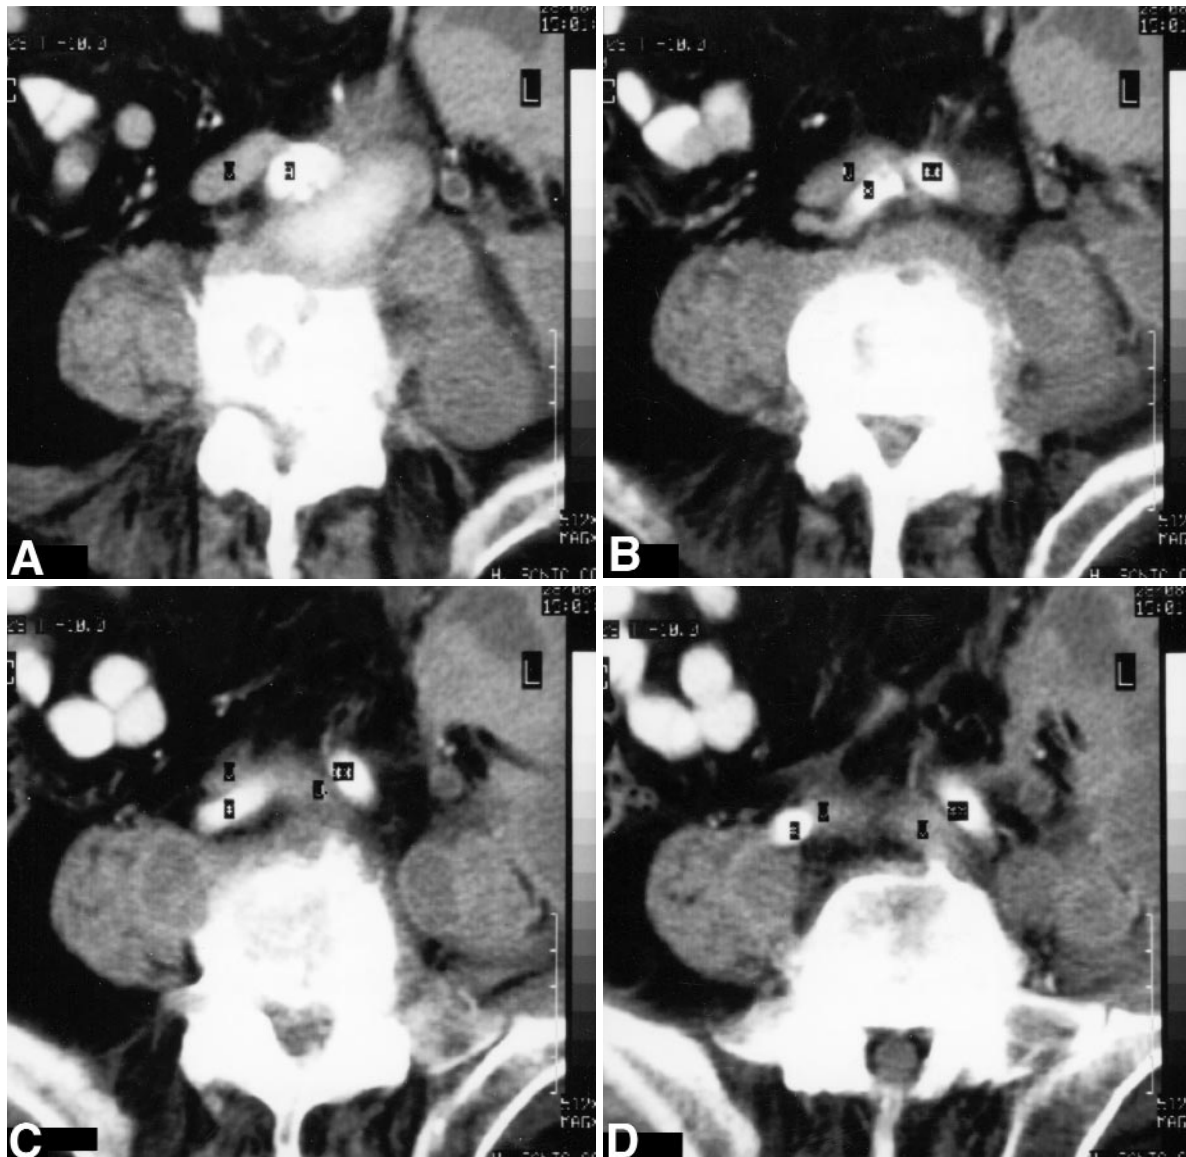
Clockwise from top left: computed tomography scan of the relationships between the caval confluence and the aorta. The thickness of the slices is 10 mm. Craniocaudal sequence. V, Vena cava, iliac veins. *Right CIA. Left CIA.
